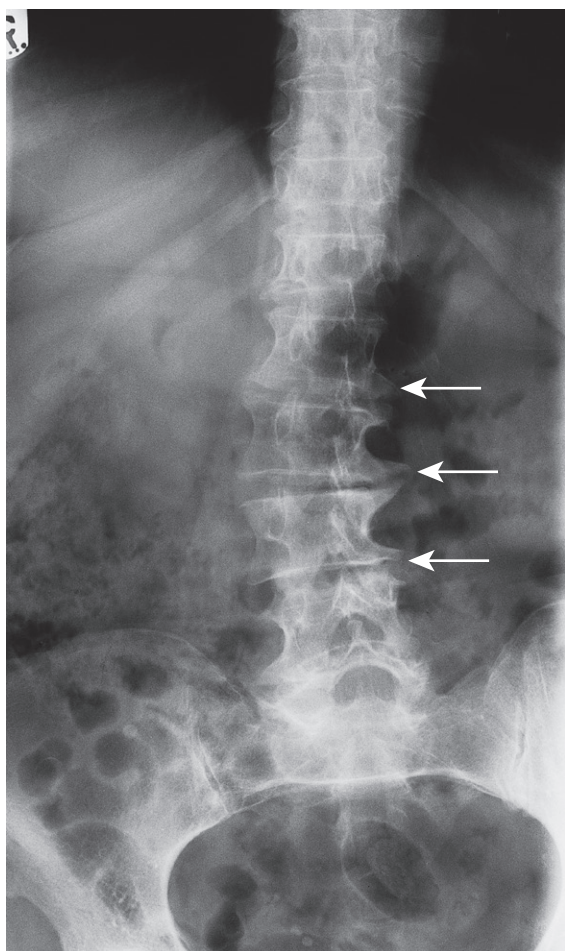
Radiograph of the lumbar spine showing flowing osteophytes in a patient with diffuse idiopathic skeletal hyperostosis
